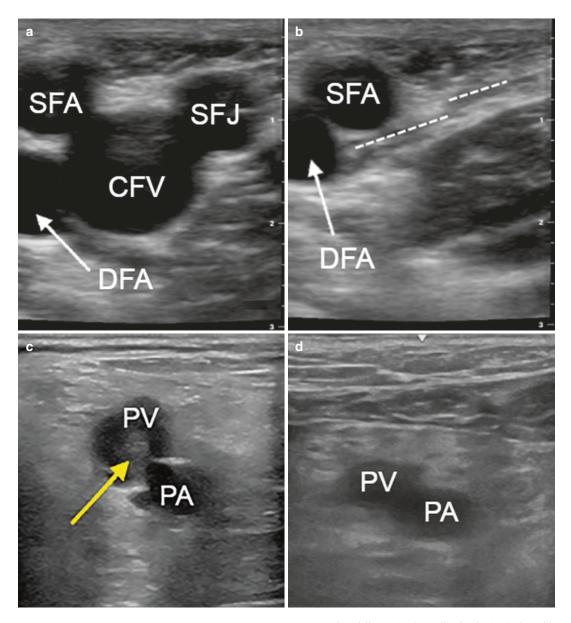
Compression ultrasonography of the lower extremity. (a) Normal anatomy of the common femoral vein (CFV), saphenofemoral junction (SFJ), superficial femoral artery (SFA), and deep femoral artery (DFA). (b) The same location, but with application of compression, showing normal obliteration of the CFV and SFJ when there is no clot
